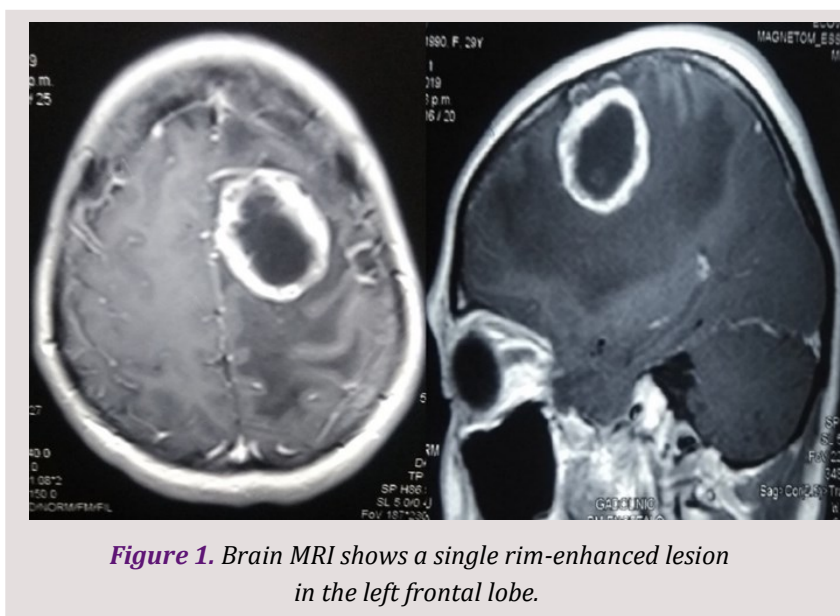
Brain MRI shows a single rim-enhanced lesion in the left frontal lobe.
